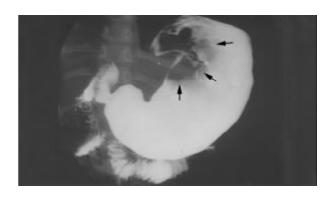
A large lobulated mass at the upper part of gastric body (arrow head) shown by radiography.
